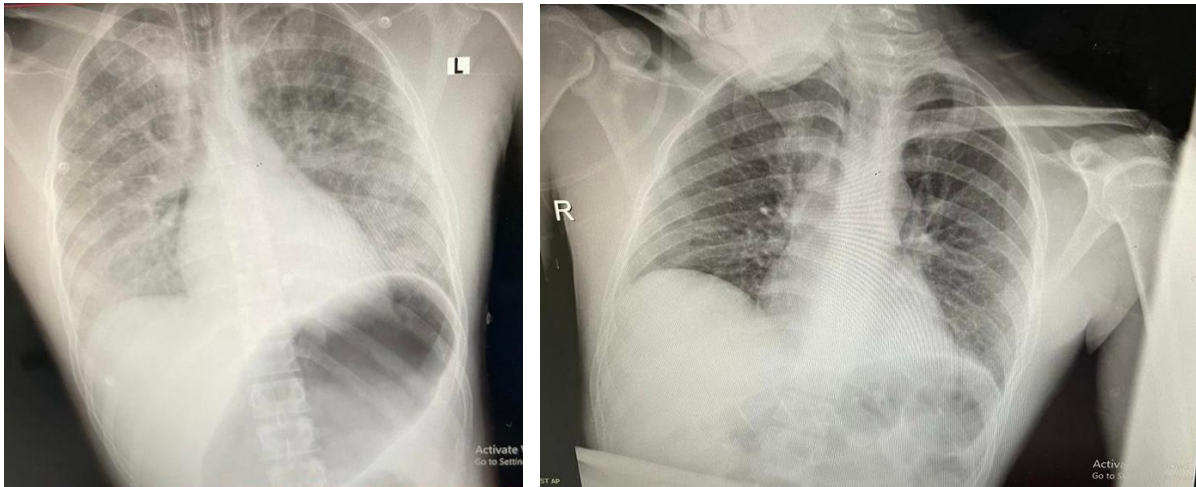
Chest X ray showing non-homogenous infiltration of both lung fields, denoting pulmonary edema; Figure 3 Follow up chest X-ray showing marked improvement following pulmonary edema.
